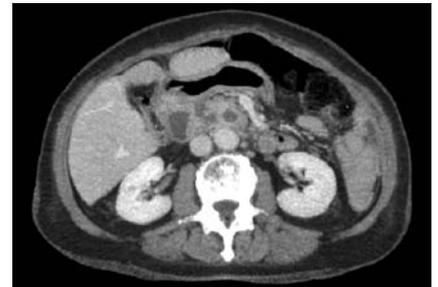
Computed tomography scan 2 days after radiofrequency ablation, showing a hypodense lesion in the pancreatic head, corresponding to the ablation area.
